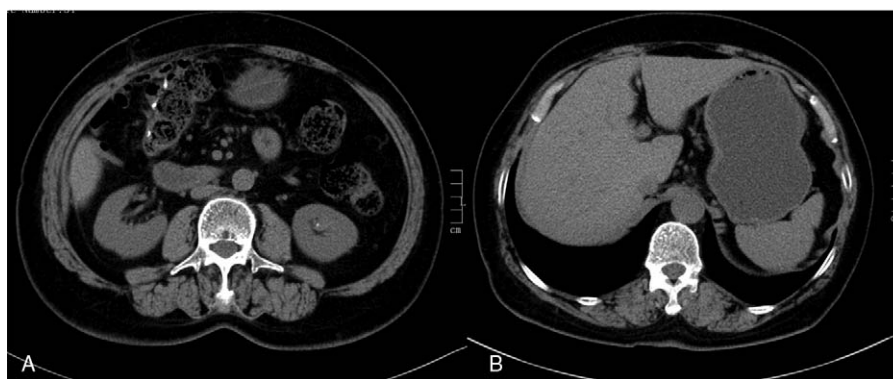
Computed tomography of the patient showing no local recurrence and distant metastasis after 5 months following surgery.
